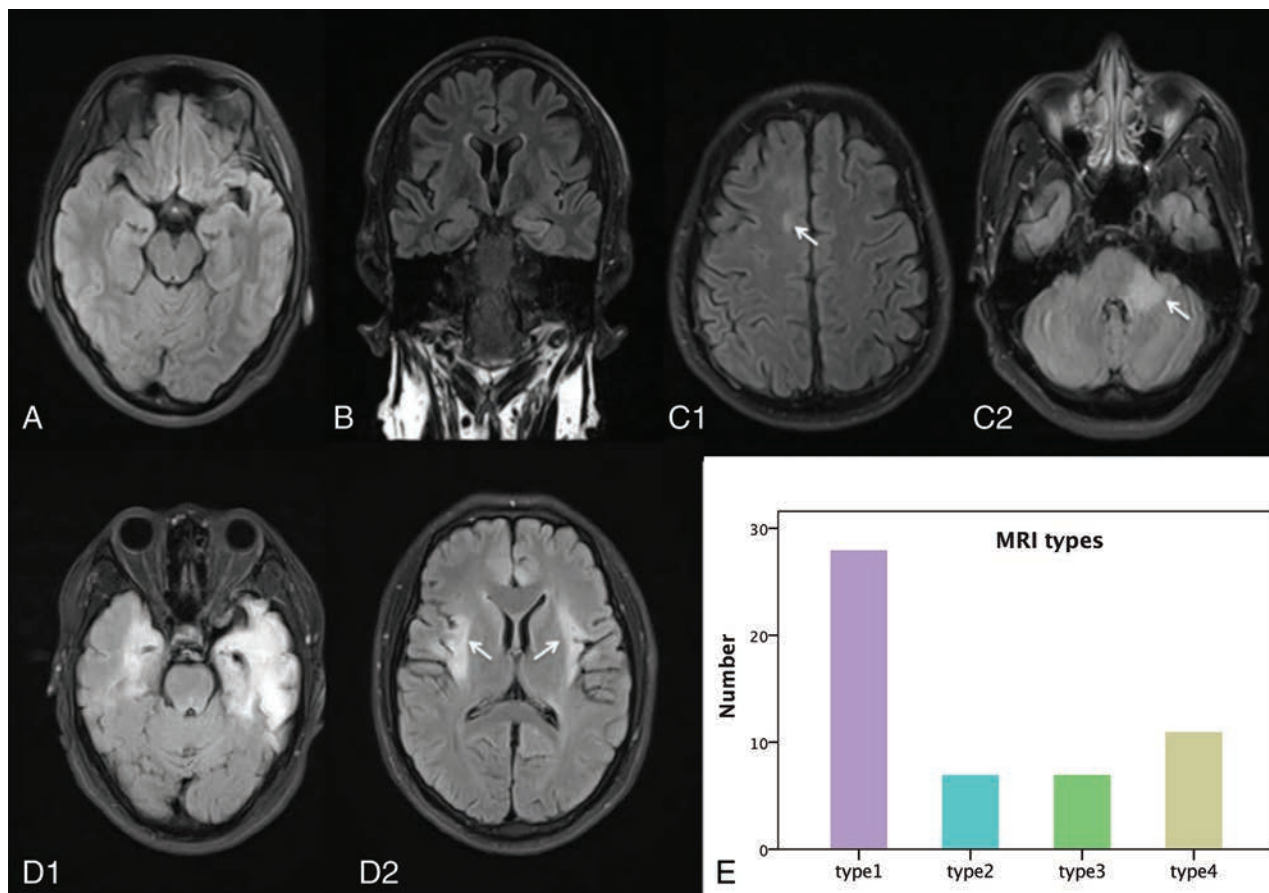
Four types of brain MR imaging appearances in patients with anti-NMDA receptor encephalitis, and the histogram of the 4 types of brain MR imaging appearance. Axial (A, C, and D) and coronal FLAIR images (B) come from 4 patients (C1 and C2 from same patient, D1 and D2 from same patient). A, Type 1, a 23-year-old male patient with anti-NMDA receptor encephalitis, with normal brain MR imaging findings. B, Type 2, a 29-year-old female patient. Lesions are in the left hippocampus with bilateral mild volume loss in the hippocampus. C, Type 3, a 28-year-old male patient. Lesions are in the right frontal lobe (white arrow) and middle cerebellar peduncle (white arrow) and brain stem. D, Type 4, a 25-year-old male patient, with lesions located in the bilateral frontal lobe, temporal lobe, insula (white arrows), hippocampus, and cingulate gyrus, with volume loss in the left hippocampus. E, Histogram of the 4 types of brain MR imaging appearances.
